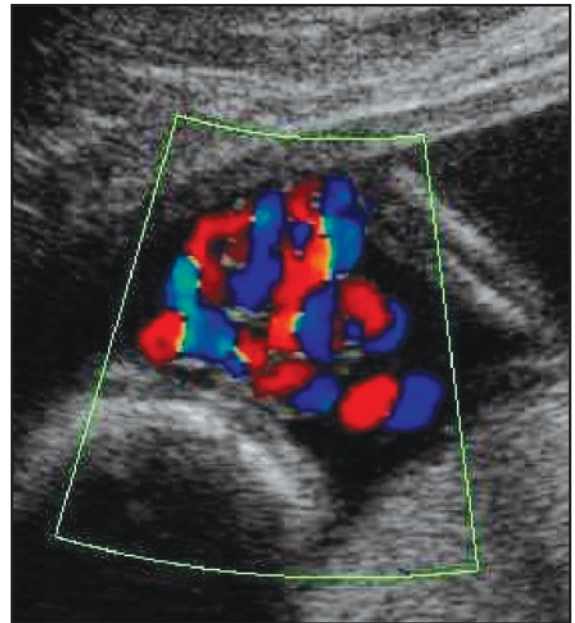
Sonogram of an umbilical cord knot. Image courtesy of Virlene Guzman, RDMS.
